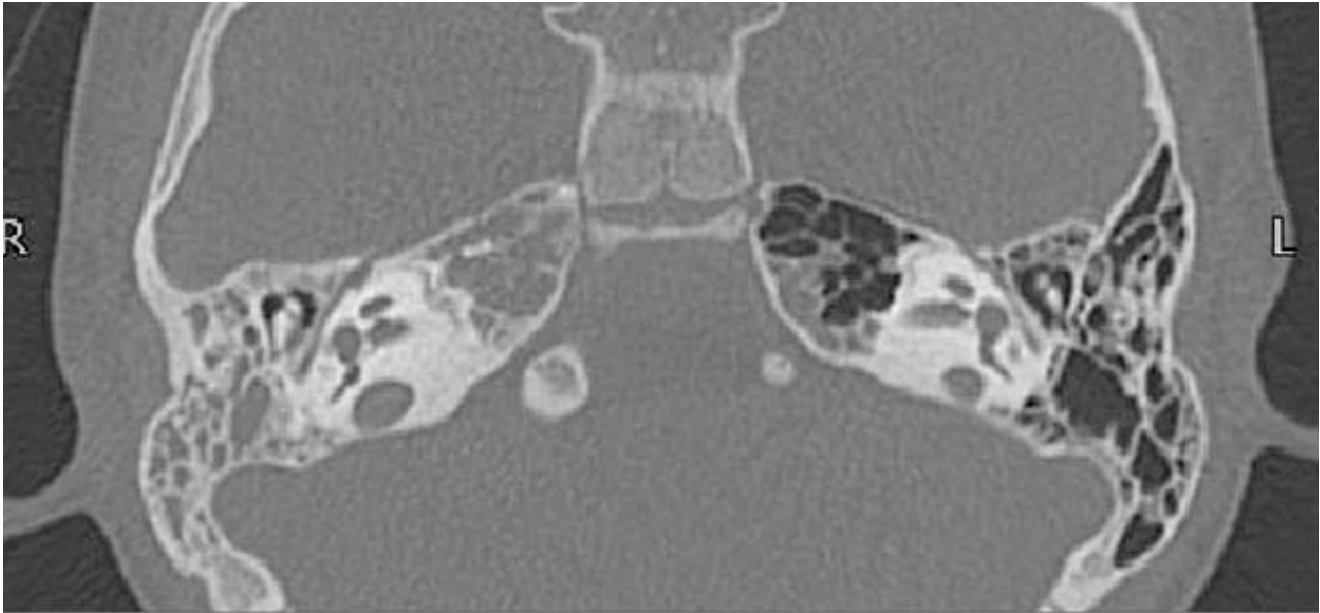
CT temporal bone showing evidence of right mastoiditis.
